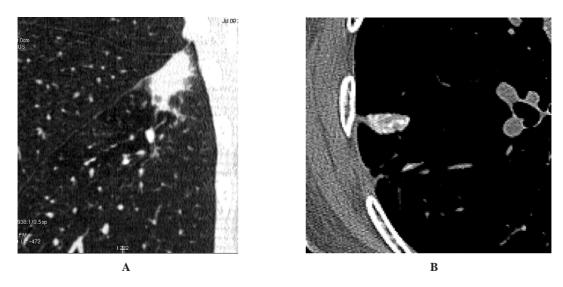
(A): Sagittal reformatted HRCT shows a spiculated mass at superior segment of right lower lobe with polygonal shape. (B): multiple punctate calcification is demonstrated. The mass was pathologically proved to be tuberculosis
